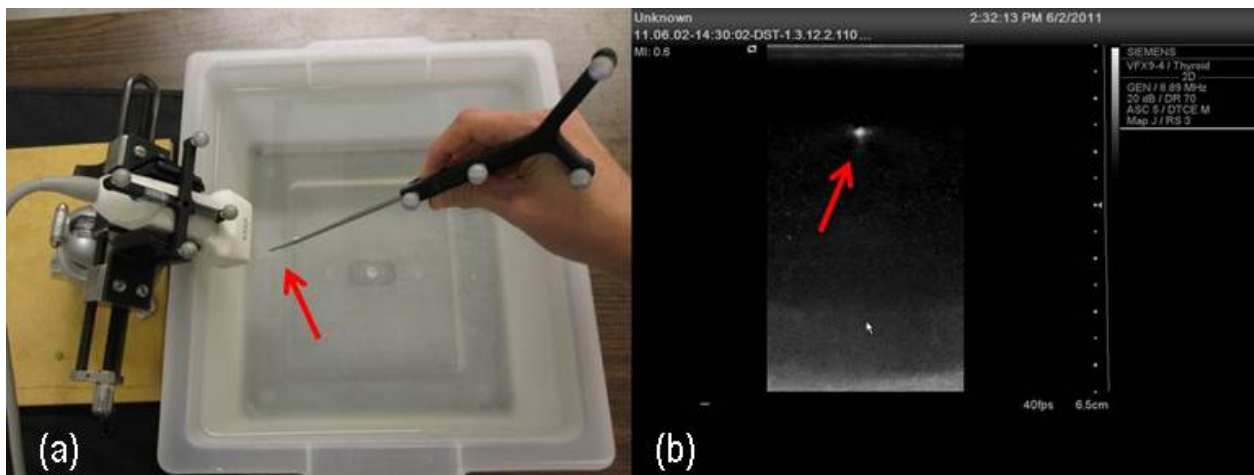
Calibration of the tracked ultrasound system. The ultrasound beam is approximated to be planar, and is sampled with a tracked pen probe (a) to produce bright corresponding points in the ultrasound images (b). A calibration transformation is computed which best matches the image points to the physical probe points.
